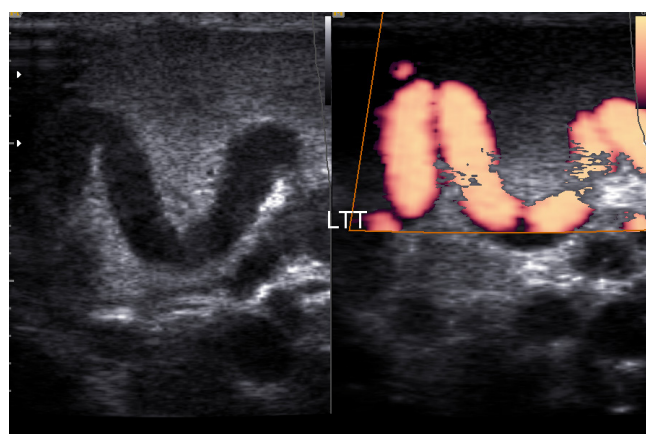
Left testis demonstrating intratesticular varicocele near the mediastinum on B-mode and power Doppler imaging
